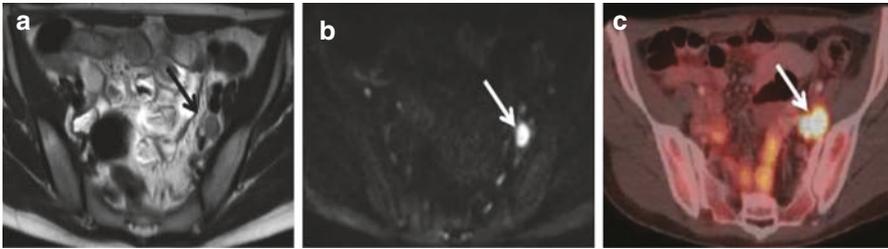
(a) T2-weighted MR image shows enlarged lymph node posterior to the right external iliac vein. The lymphadenopathy is markedly hyperintense compared to surrounding lymph nodes on the (b) b1000 DWI-image facilitating its detection. The lymphadenopathy was confirmed by (c) PET/CT and subsequent lymphadenectomy
